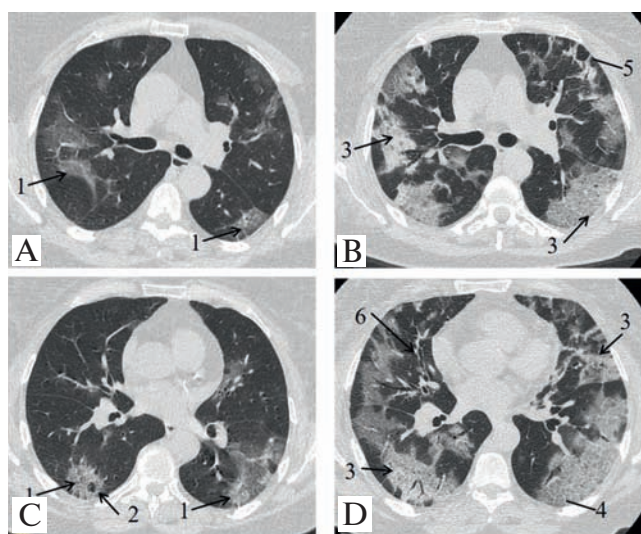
Patient N., 61 years. Moderate COVID-19. Computed tomography, axial slices; A, B, 8th, and C, D, 15th days of the disease. Clinically the patient is stable. A, B, few subpleural inhomogeneous ground glass foci (1) with sporadic secondary lobules with preserved aeration (2). Damaged pulmonary area is about 40%; C, D, multiple confluent areas of increased attenuation (3) predominantly on the periphery; crazy paving symptom (4), perilobular reticular pattern (5), dilated segmental bronchi (6). The lung involvement is about 70%
